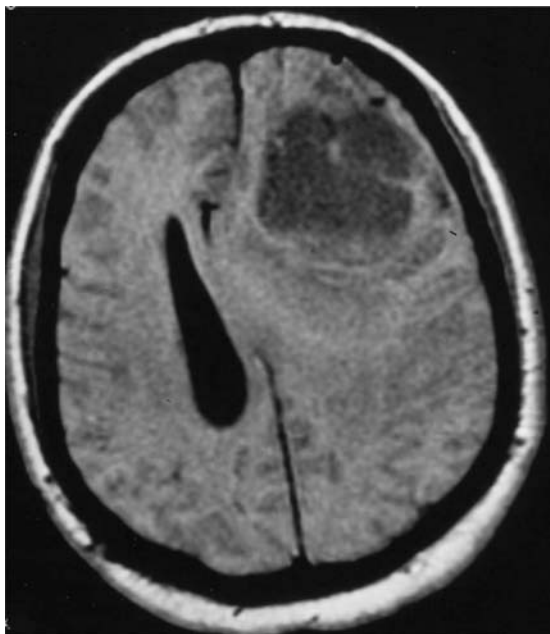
Hypodense frontal lesion, MRI. From the Neuroradiology Unit, Dpt Neuroscience, University of Turin
